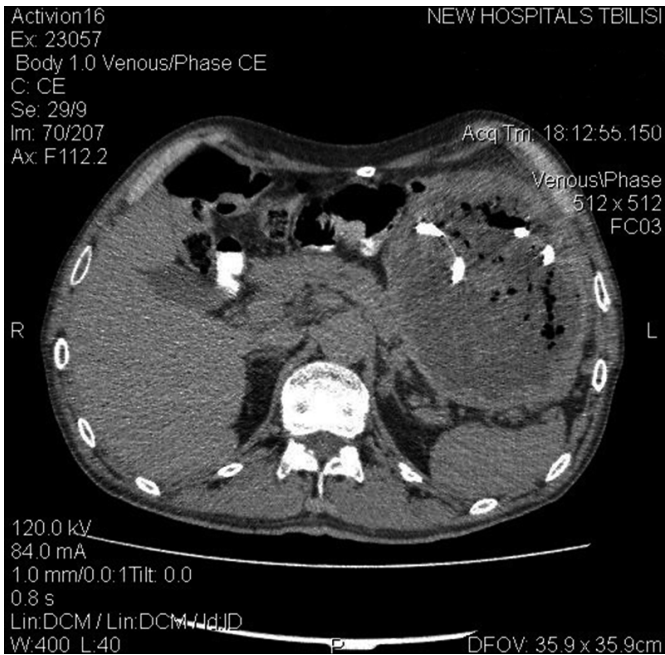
CT image shows large mass lesion with fluid collection and air components with mimicks an abscess after the drainage procedure.
